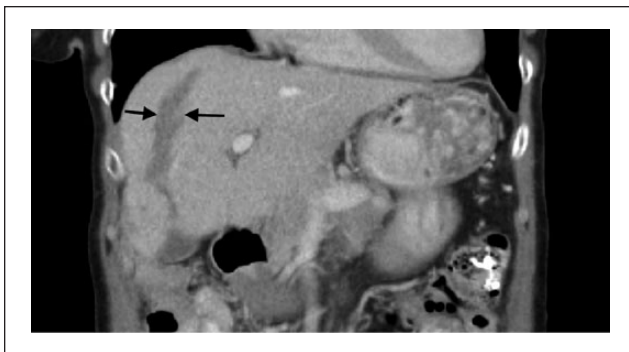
Computed tomography scan of October 10, 2015: Continued regression, significantly improved hepatic tissue.
